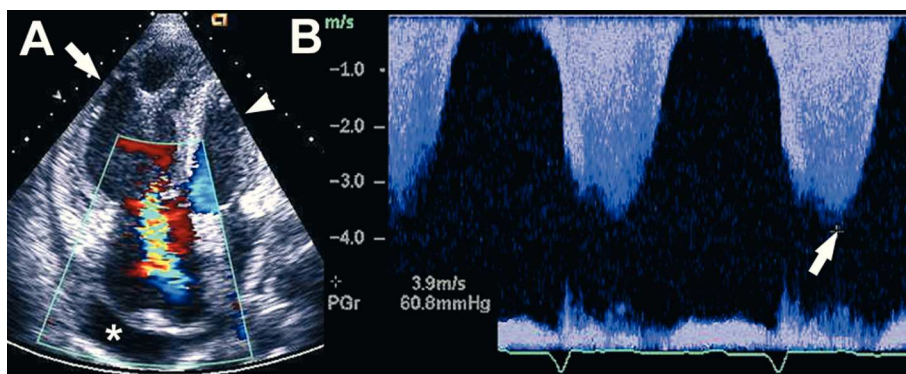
A: four-chamber view of a 2D echocardiogram in a patient with severe pulmonary hypertension demonstrating an enlarged right ventricle (white arrow), a small left ventricle (white arrowhead) and flattened septum. A pericardial effusion is indicated by the asterisk. In addition, color Doppler demonstrated the presence of tricuspid regurgitation. B: continuous Doppler recording of the tricuspid regurgitation jet allows measurement of a regurgitant peak velocity (white arrow) of 3.9 m/s or a calculated peak pressure gradient of 60.8 mm Hg between the right ventricle and the right atrium.
